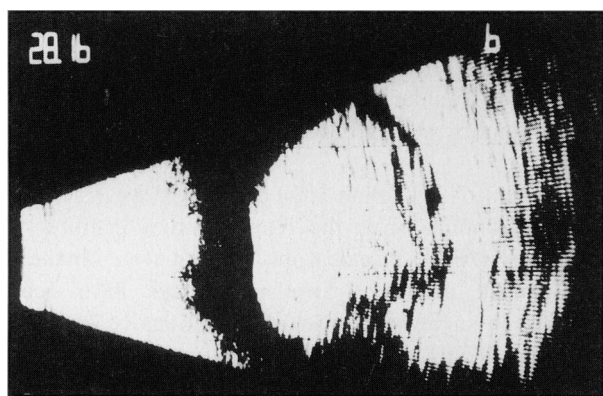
B-scan ultrasound of a large, dome-like choroidal melanoma.
